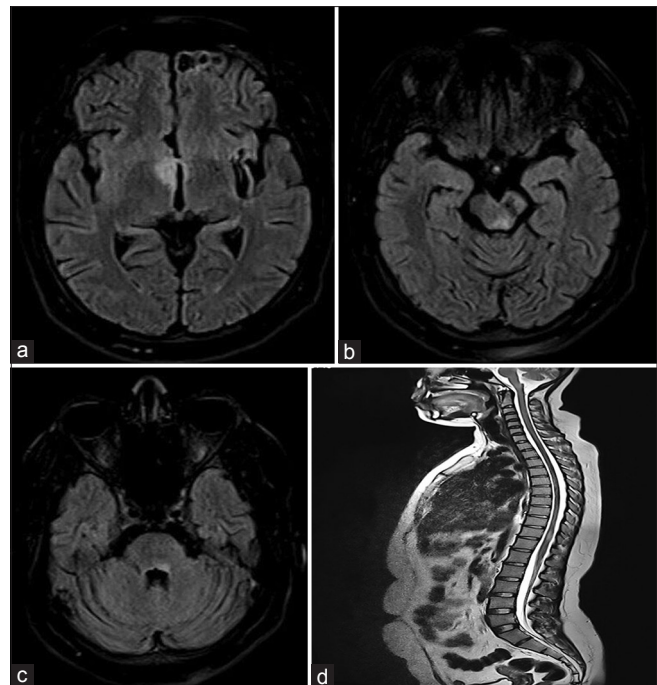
(a) Fluid-attenuated inversion recovery magnetic resonance imaging showing hyperintense signal changes in hypothalamus. (b) Fluid-attenuated inversion recovery magnetic resonance imaging showing hyperintense signal changes in periaqueductal gray. (c) Fluid-attenuated inversion recovery magnetic resonance imaging showing hyperintense signal changes in pontine tegmentum. (d) T2 sagittal magnetic resonance imaging of spine showing hyperintense lesion at D10 vertebra
